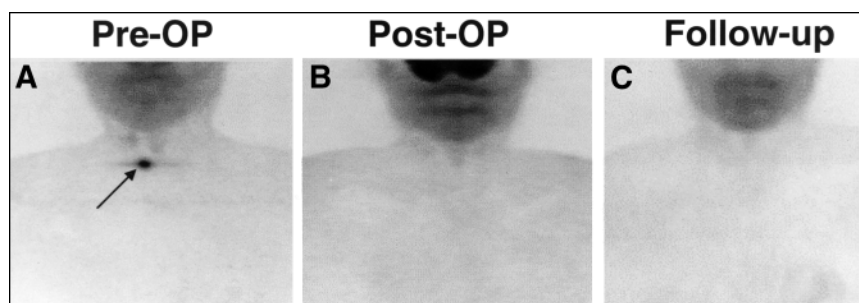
FDG-positive local recurrence (arrow) in 49-y-old man who presented with negative ¹³¹I scan after thyroidectomy and two courses of radioiodine treatment of papillary thyroid cancer initially staged as pT2bN0M0 (A). No tumor remnants were seen after further surgery (B) and during follow-up (C). Consequently, hTg levels dropped from 30 μg/L (preoperative) to 5 μg/L (postoperative) and 11 μg/L (follow-up). Images show maximum-intensity projections in anterior views.
